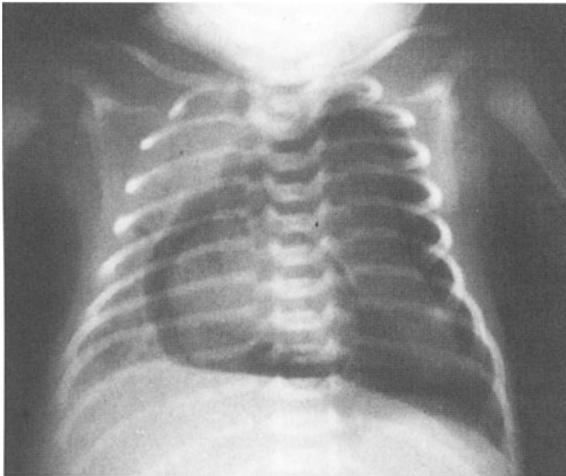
Chest radiograph from a baby at 28 weeks gestation; there is air within the left pleural and pericardial cavities.
